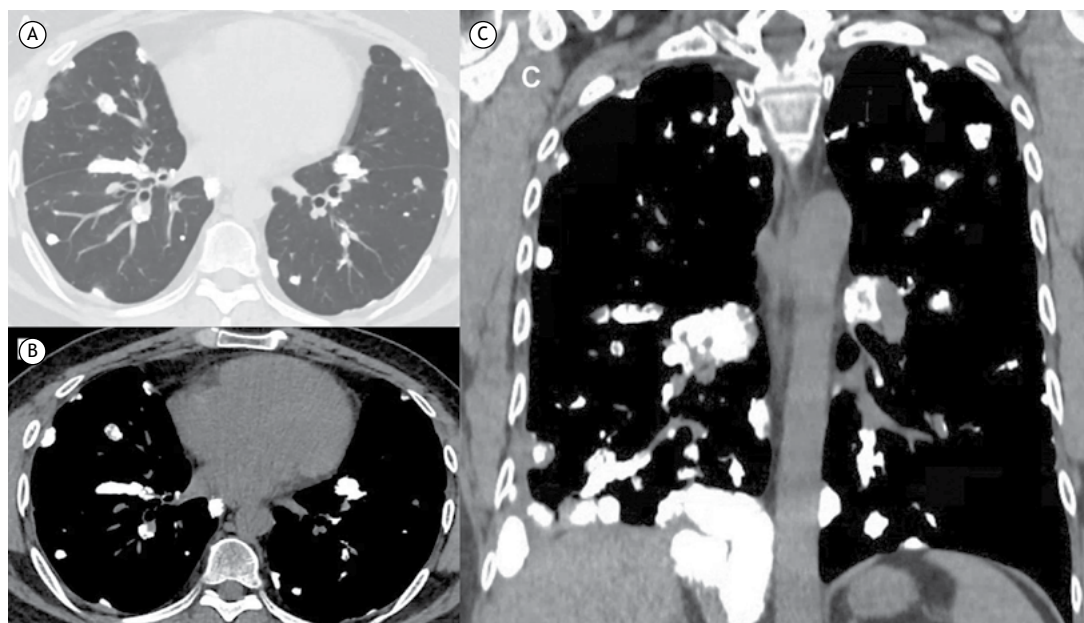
A 44-year-old man with primary osteosarcoma of the femur. In A, B, and C, CT scans showing multiple calcified nodules and masses in both lungs.
